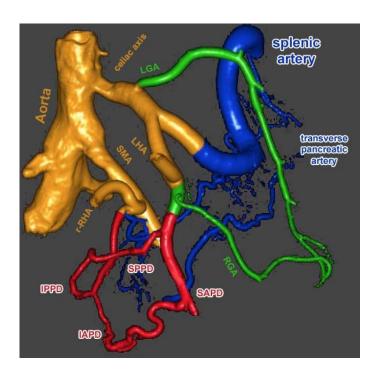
3D CT reconstruction of organ complex No. 25. Michels III: r-RHA from SMA.
